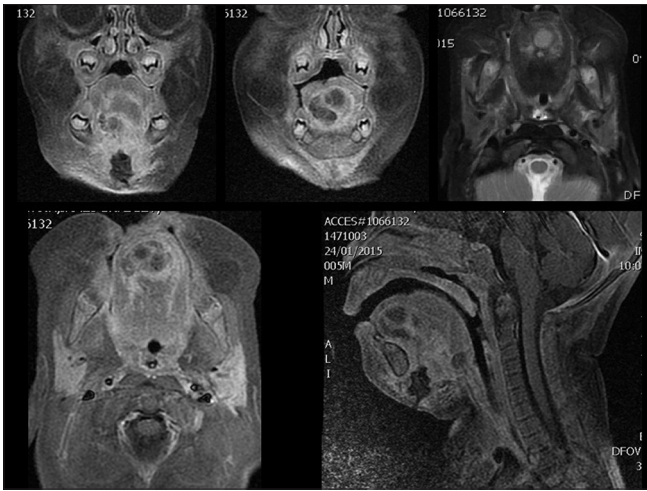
Magnetic resonance imaging shows multicystic mass with inflammatory signs, reaching from the floor of the mouth to the base of the tongue
